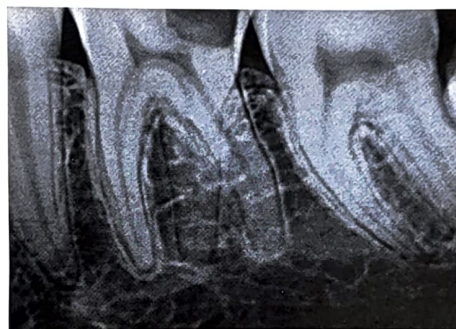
CASE II: Preoperative radiograph
